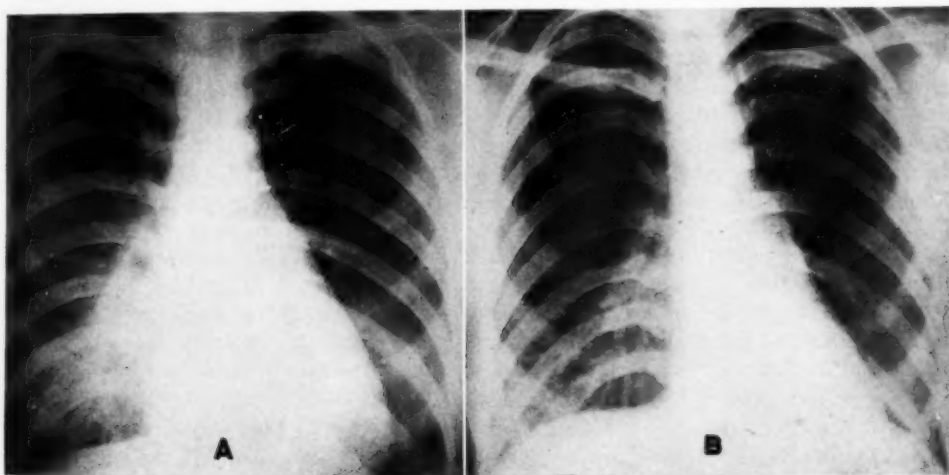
Acute pneumonia in the right middle lobe. A. Roentgenogram with normal pressure. B. Roentgenogram with high pressure.
